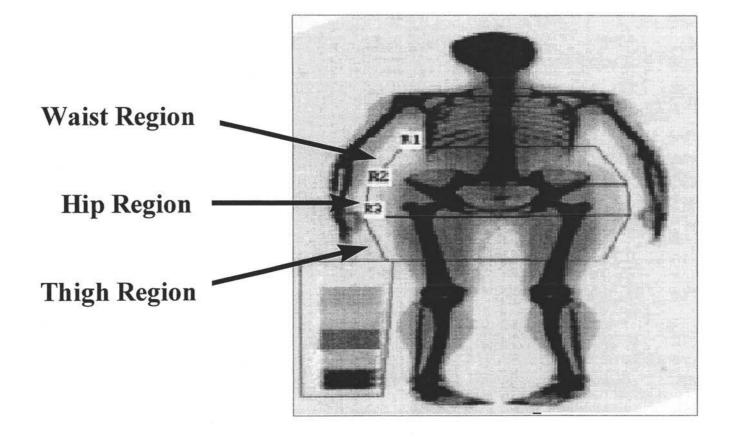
Regional analysis of whole body dual-energy x-ray absorptiometry scan. Waist, hip. and thigh regions were manually set based on skeletal landmarks following the regional DXA analysis protocol developed and modified by Farrell-Lee (1995).
